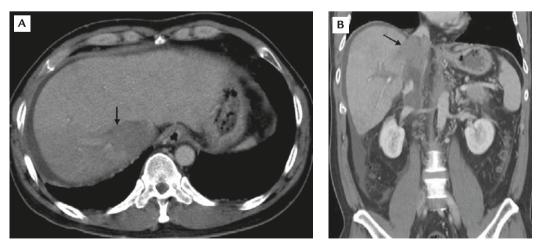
Abdominal computed tomography shows contrast-filling defects within the (A) right hepatic vein (arrow) and (B) intrahepatic segment of the inferior vena cava (arrow), compatible with tumor thrombus.
